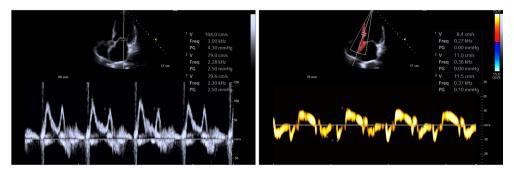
Figure nr. a.2.7. A case with type 2 of diastolic dysfunction. Left: transmitral flow indicates a E/A ratio> 1 (E=104 cm/s; A=79 cm/s) that can be false interpreted as normal (PW Doppler, 4-chambers view). Right: septal myocardium tissue Doppler indicates an  $e'_s/a'_s$  ratio < 1 revealing no "pseudonormalisation" pattern. In this case E/e'\_s=12.3, a value that suggests increased telediastolic LV pressure.
